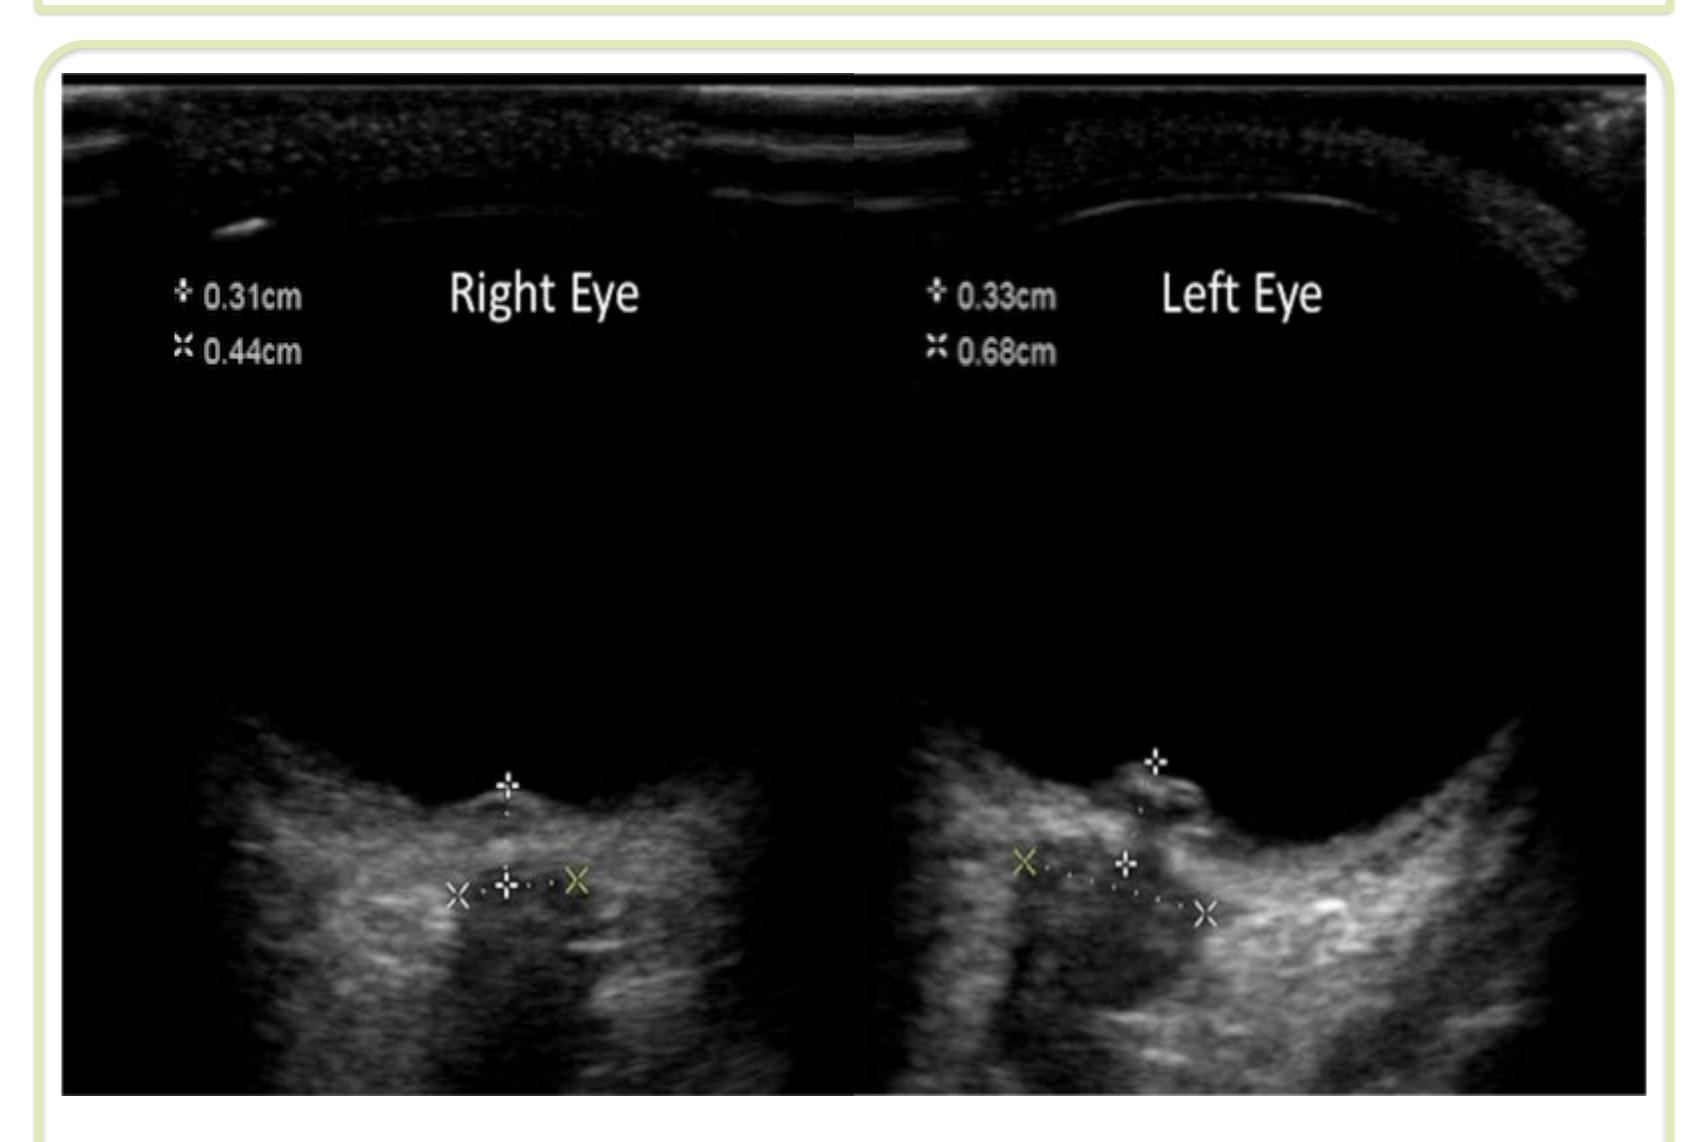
Ocular ultrasound with bilateral papilledema and dilated left optic nerve sheath diameter
